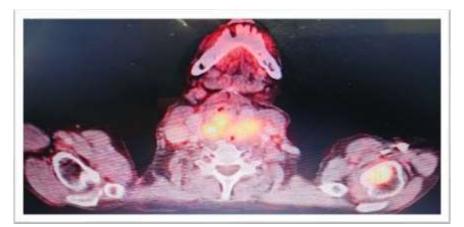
PET-CT IMAGE SECTION SHOWING FDG AVID LESION IN HYPOPHARYNX WITH ENLARGED NODES AND ANOTHER FDG AVID LESION IN LEFT HUMERUS [RED ARROW].
